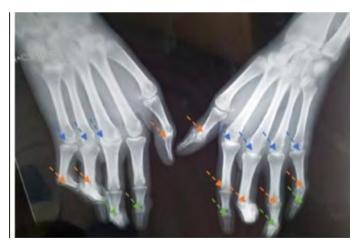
Standard x-ray of the hands, showing joint space narrowing in the metacarpophalangeal joints (3rd,4th,5th right and 2nd,3rd,4th,5th left), joint space narrowing in all the PIP joints (1 st, 4th, 5th right and 1st, 2nd, 3rd, 4th, 5th left) and DIP joints (1st, 2nd right and 1st, 3rd, 4th left), with anterior dislocation of the 3rd, 4th right DIP and 2nd left DIP; as well as geodes and erosions on the interphalageal joints bilaterally
